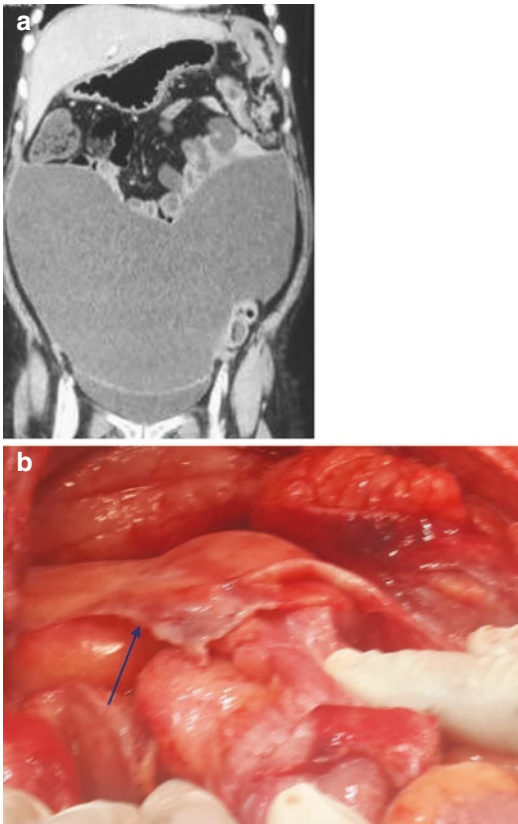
(a) CT image of a fibrous cocoon in a patient who received intraperitoneal cisplatin through a port. (b) Intraoperative photograph of the same patients showing the thickened membrane covering the bowel (blue arrow)
